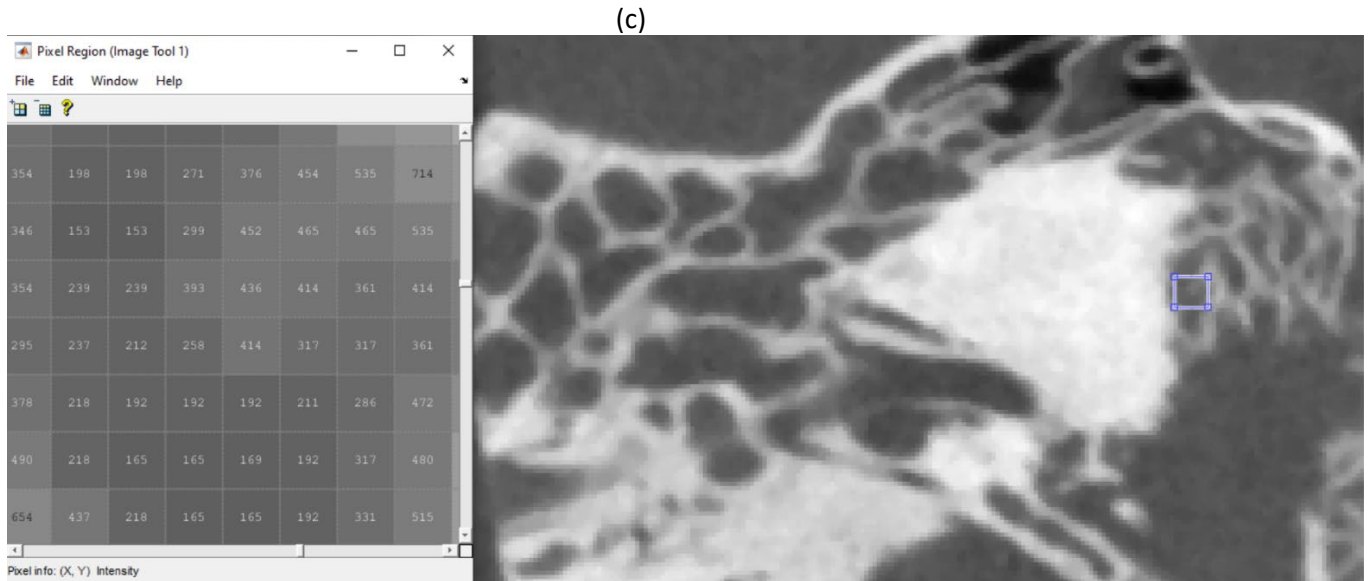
The points chosen in the Micro CT: (a) air, (b) bone, (c) soft tissue, (d) another soft tissue.
